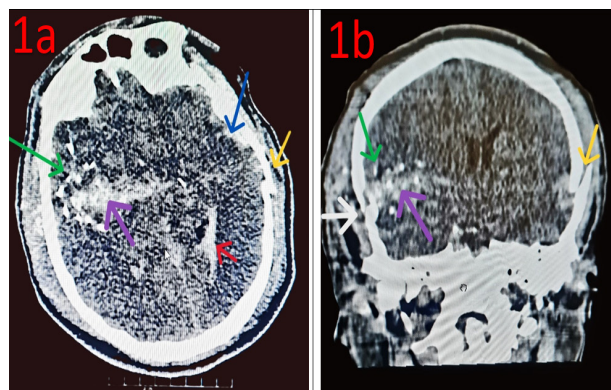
axial CT scan, Figure 1b coronal CT scan show green arrow: retained bone; white arrow: entry; yellow arrow: exit; purple arrow: ICH, intracerebral hematoma; red arrow: IVH, intraventricular hematoma; blue arrow: SDH, subdural hematoma
